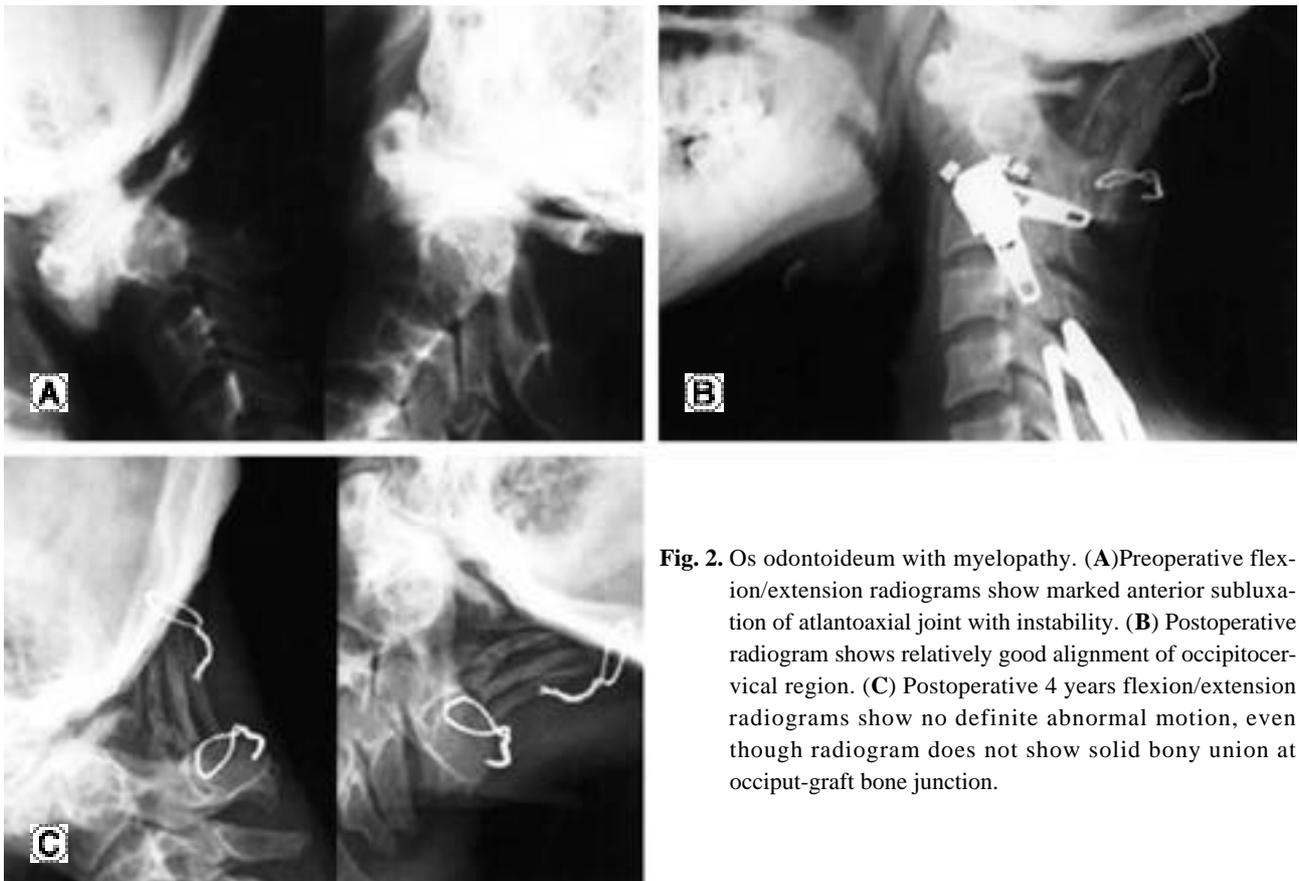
Os odontoideum with myelopathy. (A) Preoperative flexion/extension radiographs show marked anterior subluxation of atlantoaxial joint with instability. (B) Postoperative radiogram shows relatively good alignment of occipitocervical region. (C) Postoperative 4 years flexion/extension radiographs show no definite abnormal motion, even though radiogram does not show solid bony union at occiput-graft bone junction.
